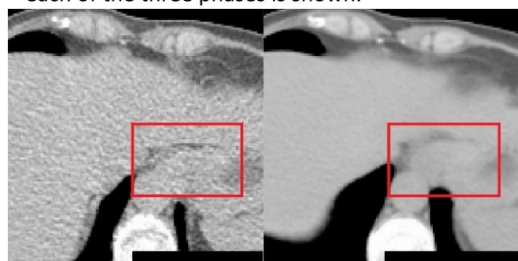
Individual phase CT image (left) compared to a motion compensated image (right) of the same region. The superior quality of the motion compensated image allows delineation of extra tumour extension - highlighted in the red box.
